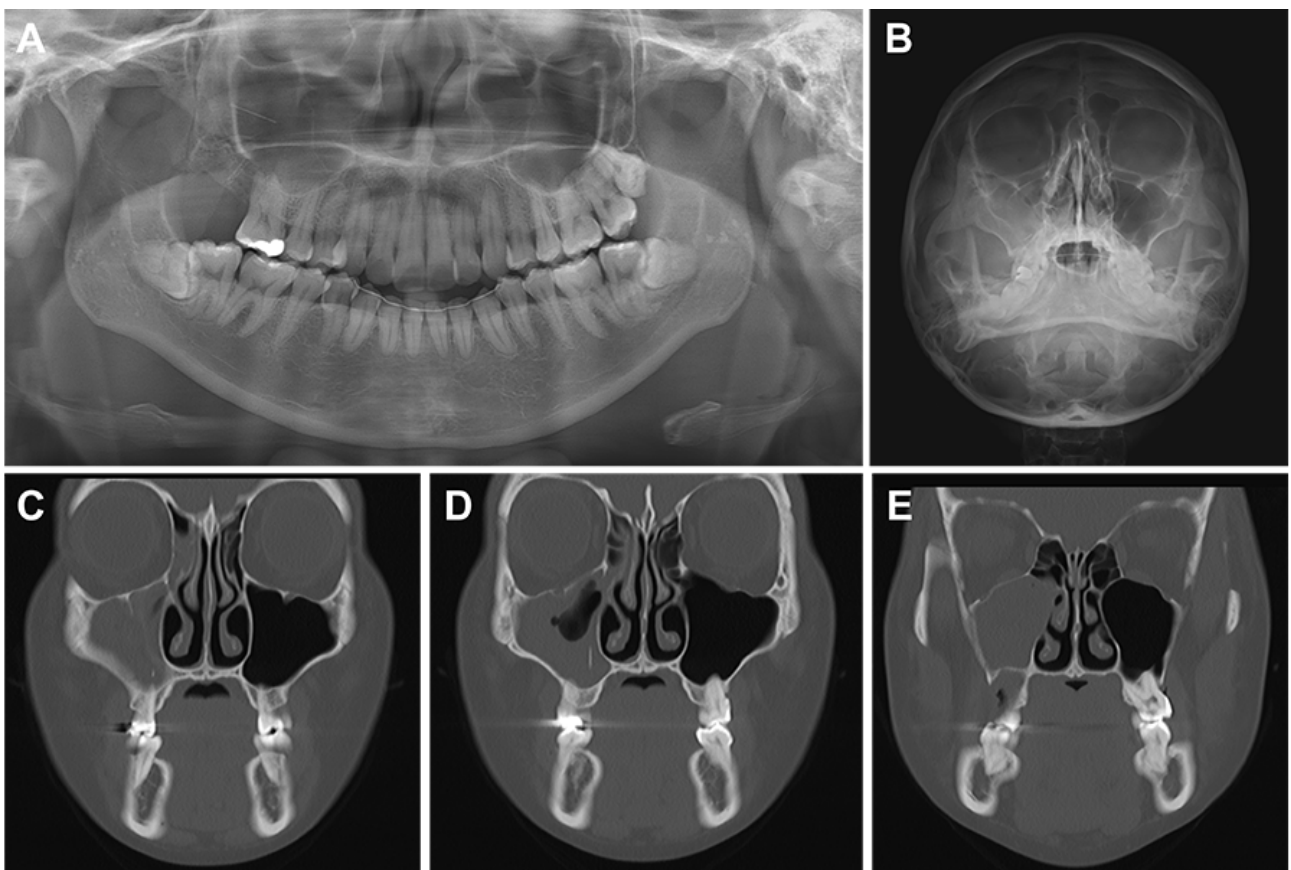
Panoramic radiograph (A), waters view (B), and computed tomography (C-E) after extraction of right upper second molar.
